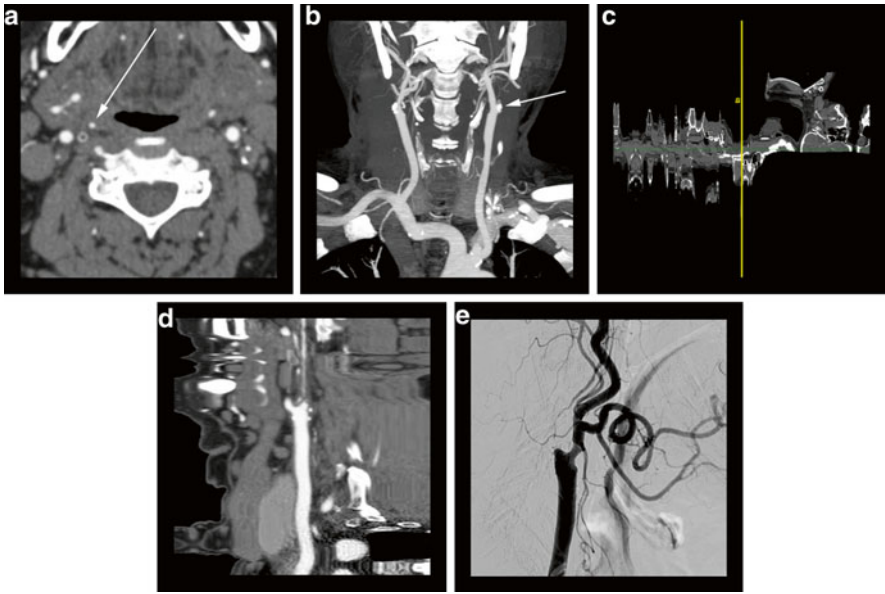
75-year-old male presenting for cerebrovascular evaluation. (a) Axial CTA image reveals a completely occluded left internal carotid artery at the origin and a critical stenosis of the right internal carotid artery origin with a residual “hairline” lumen (*arrow*). (b) Coronal CTA MIP image reveals prominent bilateral external carotid arteries with poor visualization of the residual right internal carotid artery. The left internal carotid artery “stump” (*arrow*) is visualized. (c) Computer generated “straightened” curved MPR reveals failure of the computer algorithm to accurately assign the centerline to the residual internal carotid artery vessel—a common pitfall seen with critical stenoses. (d) “Straightened” curved MPR of the same vessel with manual assignment of the centerline depicts the long segment of critical stenosis. (e) Lateral projection digital subtraction angiography of the right carotid artery with injection of the common carotid artery reveals long segment critical stenosis of the proximal right internal carotid artery as seen best in (d)
